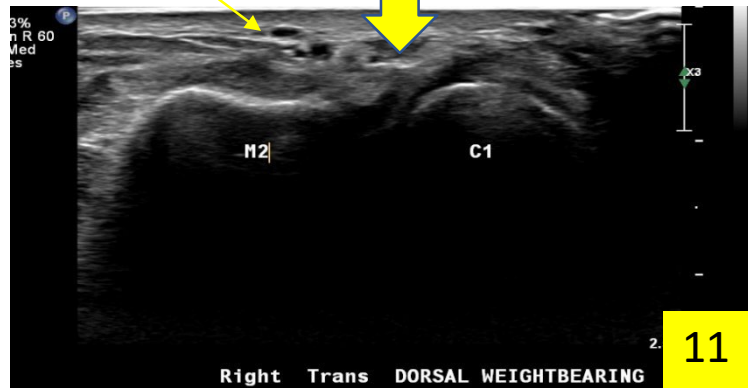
Ultrasound of injured dorsal band of Lisfranc ligament with patient weightbearing.⁸
